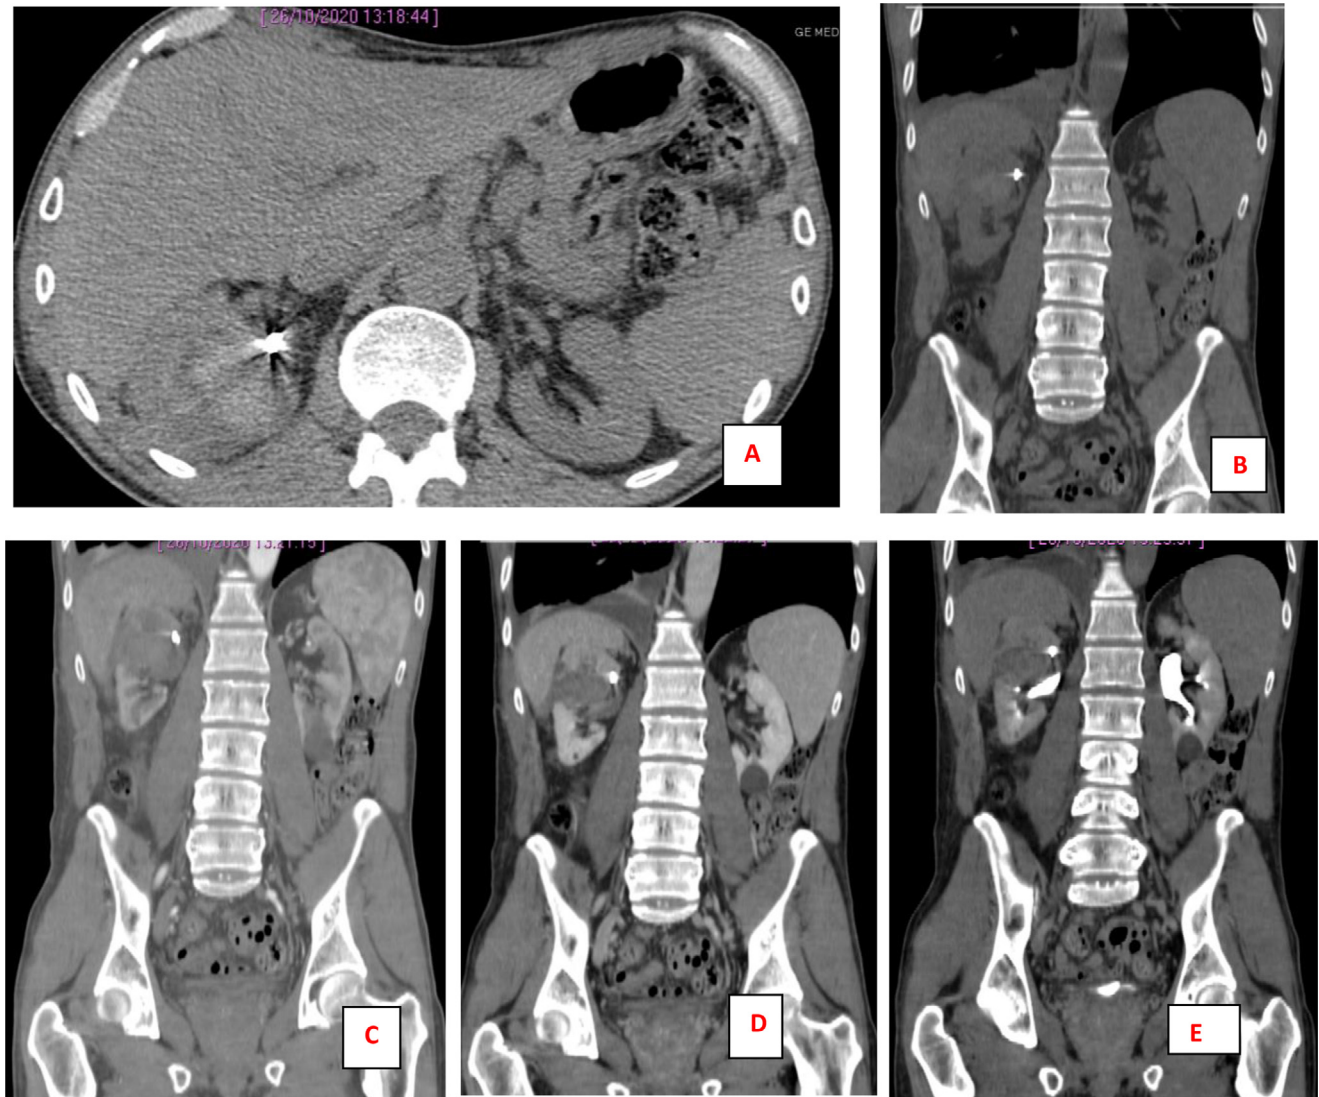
(A-B) basal CT phase just showed the presence of the spiral with the complete exclusion of the pseudo-aneurysm. (C) cortical CT phase; (D) nephrographic CT phase, and (E) late 8 minutes CT phase, that showed any active contrast spreading in the peritoneal cavity.
